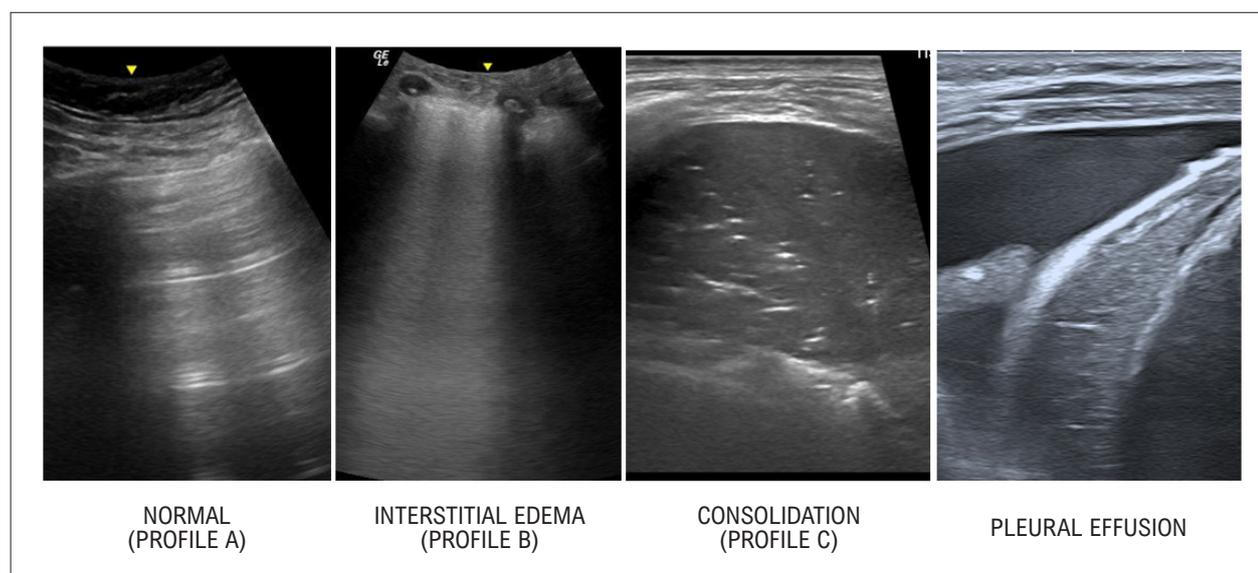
Lung ultrasound profiles described in the BLUE protocol.
